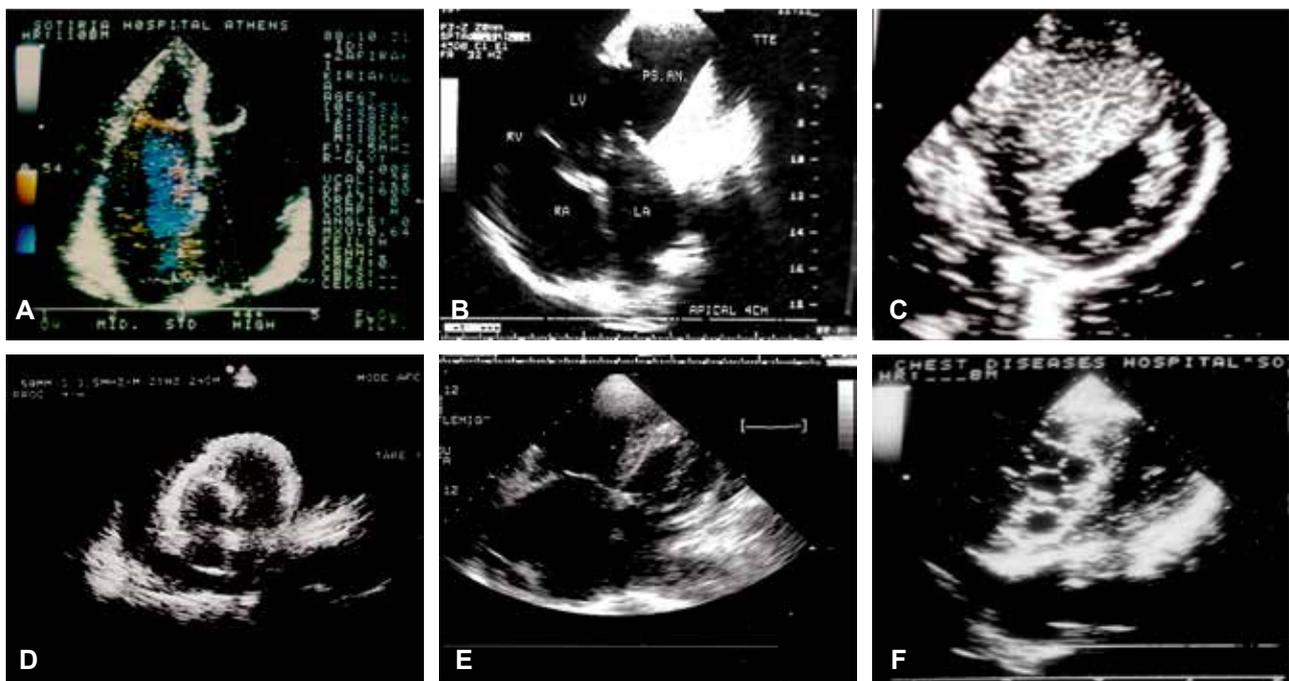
Echocardiography plays a crucial role in setting the final HF diagnosis. a) Restrictive cardiomyopathy (increased cardiothoracic ratio on chest x-ray and biatrial dilatation on echocardiogram), b) left ventricular pseudoaneurysm following previous myocardial infarction, c) hypertrophic cardiomyopathy, d) pericardial effusion with cardiac tamponade, e) right atrial and right ventricular dilatation with pulmonary hypertension, f) right ventricular hydatid cyst in a patient with right heart failure.
